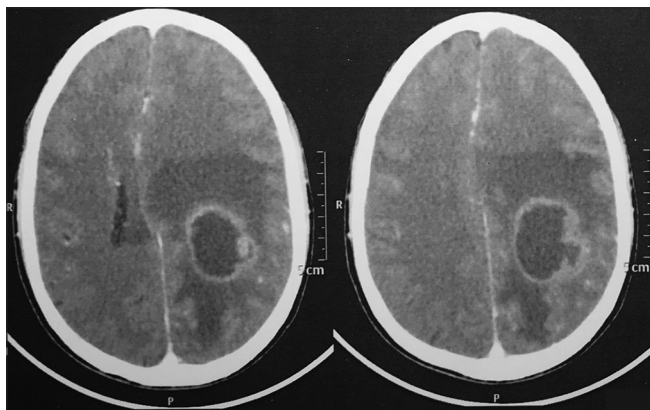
T1-weighted magnetic resonance imaging image showing a well-defined hypodense lesion in the left parietal lobe with rim enhancement, disproportionate perilesional edema, and midline shift of 8 mm
